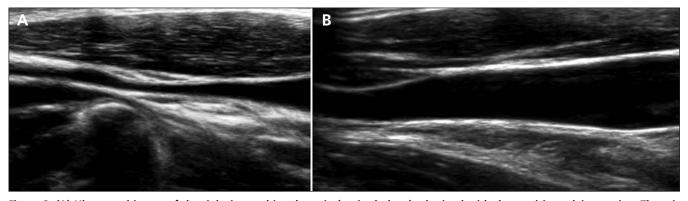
(A) Ultrasound image of the right internal jugular vein (sagittal plane), obtained with the participant lying supine. There is narrowing of the internal jugular vein that would be interpreted as abnormal according to the proposed ultrasound criteria for diagnosis of chronic cerebrospinal venous insufficiency.³⁴ (B) Ultrasound image of the same vein obtained a few minutes later, from the same participant in the same position, shows that the vein is normal and does not have fixed narrowing. Observation of narrowing in Figure 2A may have been due to compression by the transducer or may have been secondary to a change in central venous pressure (e.g., from a change in phase of respiration or in cardiac output).
